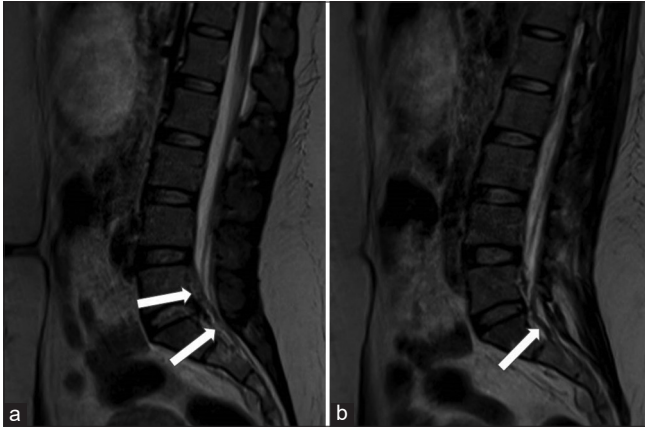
T2-weighted sagittal MRI (a and b) shows enlarged lumbar epidural plexus (white arrows).
